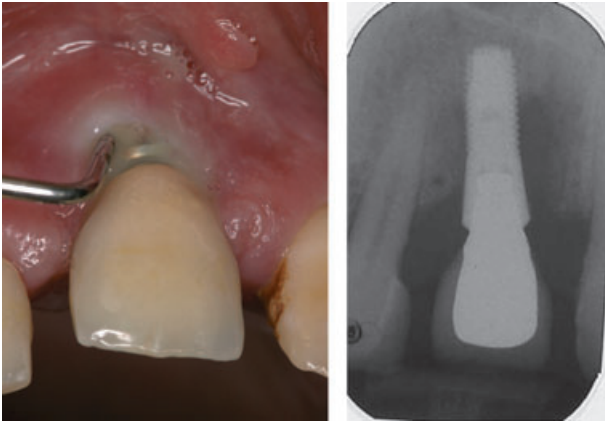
Clinical and radiographic image of a peri-implantitis lesion characterized by deep probing depth, suppuration and a radiographic peri-implant osseous defect.
